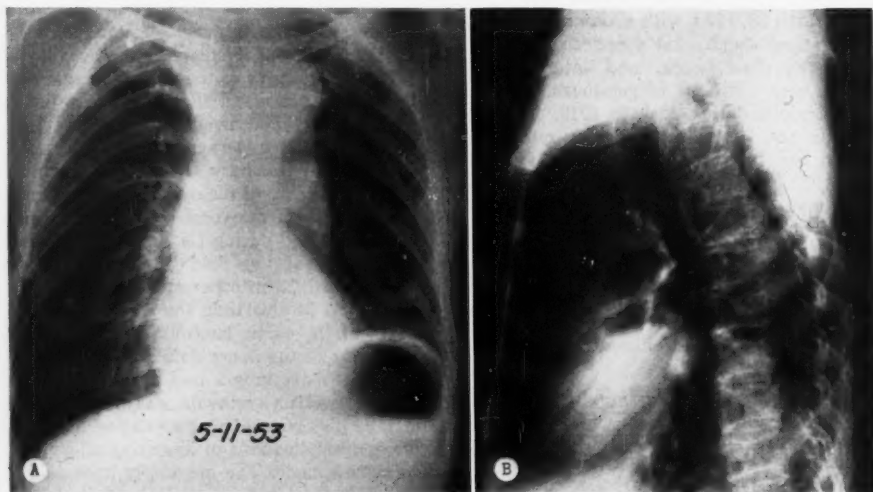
Chest roentgenogram showing increased width of aorta and paralysis of left leaf of diaphragm. A. Posteroanterior projection. B. Left lateral projection.
